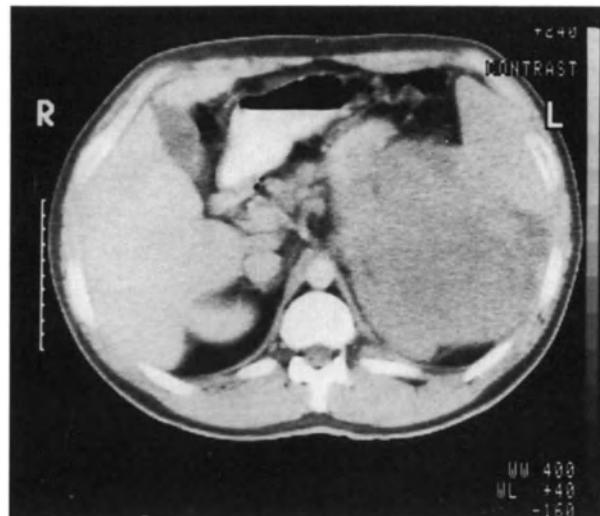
CT scan enhanced. Large lymphomatous deposit of relatively low density in the spleen. Young man with T-cell lymphoma.
